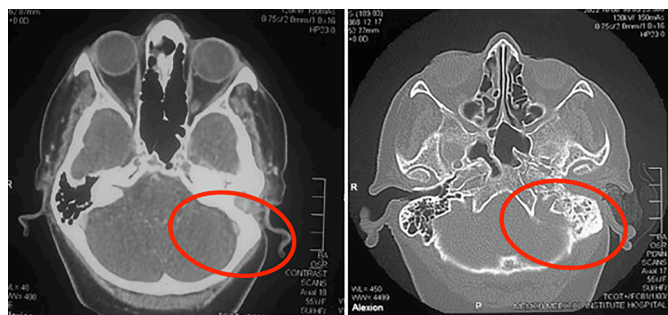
CT scan of temporal bone with contrast (axial view). Right: Red outlined circle shows soft tissue mass occupying left external auditory canal and middle ear cavity with erosion of ossicles; left: Mastoid air cells are sclerotic.
